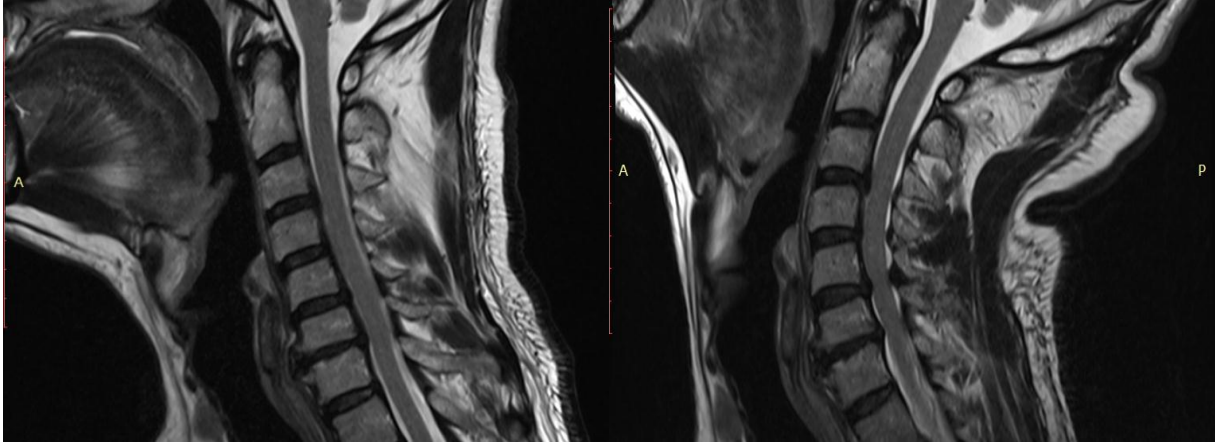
Increased number and degree of compression levels and aggravated spinal cord impingement based on extension magnetic resonance images.
